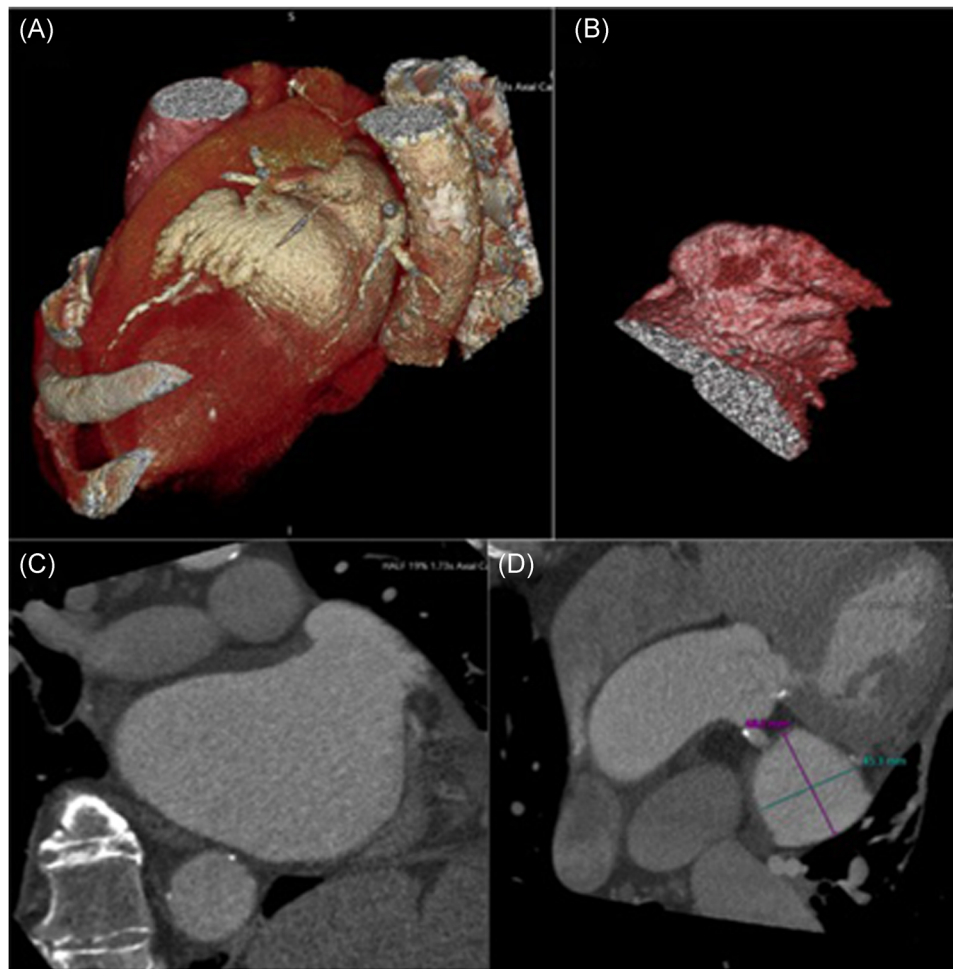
(A–C) Preprocedural CCTA showing a gigantic multilobed LAA. (D) LAA ostium with diameters measuring 48 mm × 45.3 mm. CCTA, cardiac computed tomography angiography; LAA, left atrial appendage
